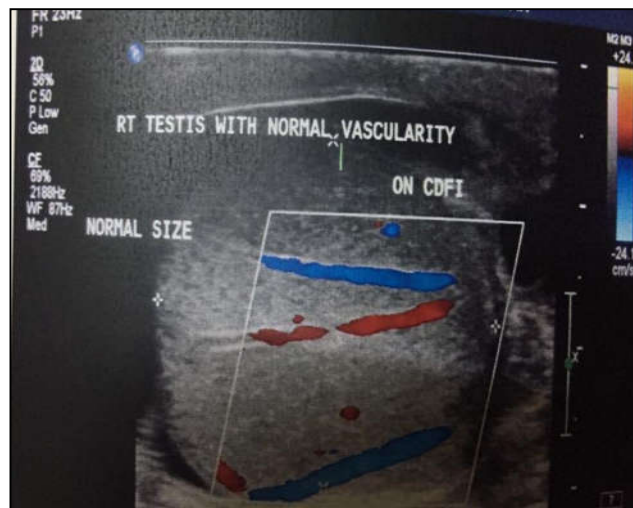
(b). Color Doppler ultrasonography showing normal blood flow in testis on right side in the same 24 years old patient.
